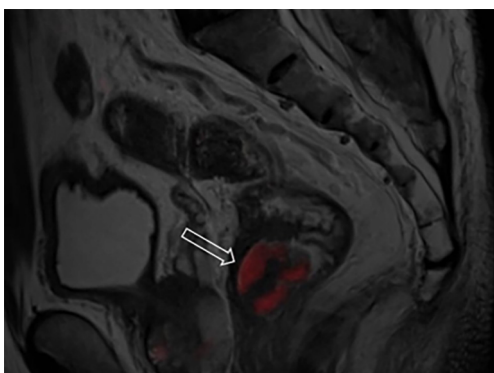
A 60-year-old man with low RC. Fused sagittal MR rectography and DWI shows the tumor with restricted diffusion in red color (arrow) without breaking through the outer membrane of the rectum. RC, rectal cancer; DWI, diffusion weighted imaging.
